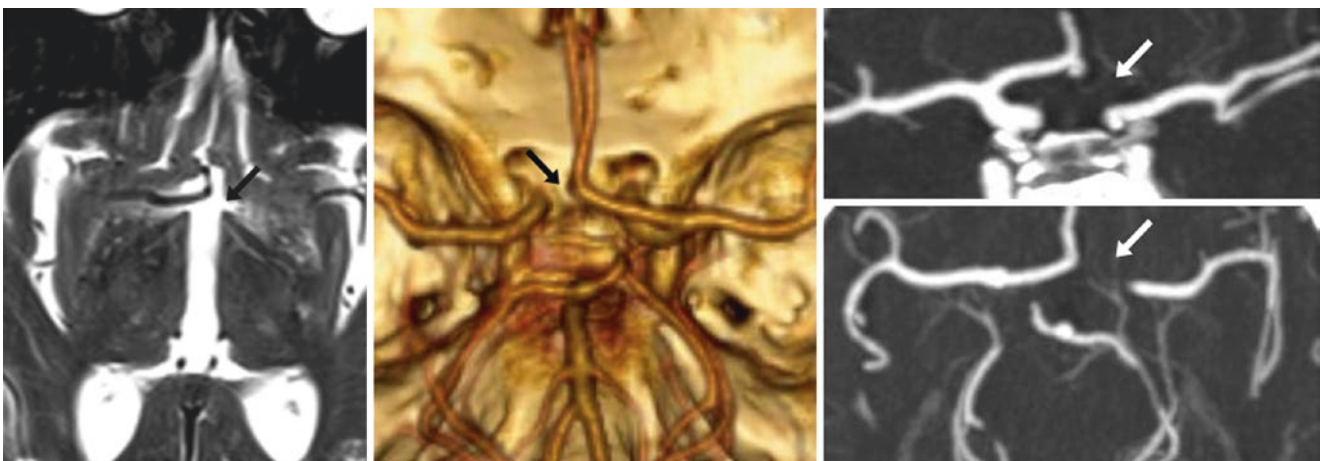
85-year-old with an absent left A1 segment (arrows) suspected on an axial T2WI MRI (left); this was confirmed on a 3D VR CTA PA view (middle), with coronal (top right) and axial (bottom right) 5-mm MPRs
